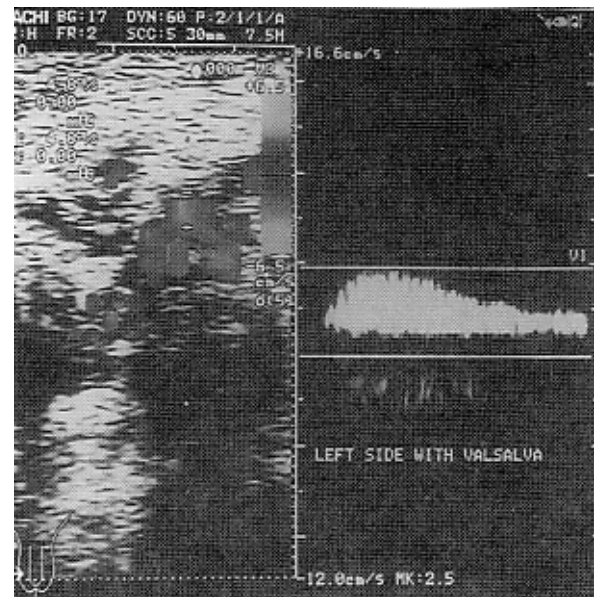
Doppler examination with score of 4 after varicocelectomy
